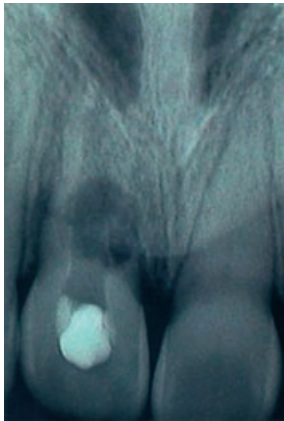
Radiographic examination 18 months after replantation showing severe replacement and inflammatory root resorption of tooth 1.1. Left upper maxillary central incisor shows narrowing of the entire root canal (pulpal canal obliteration) and normal root development.
